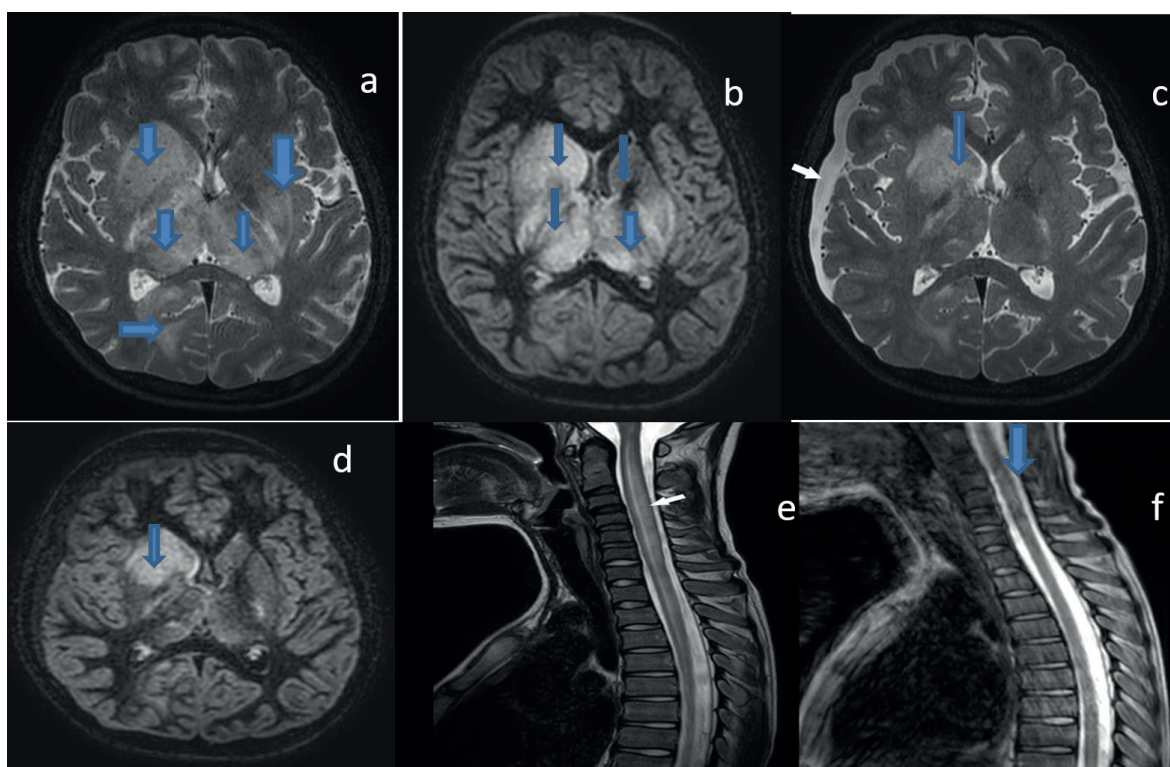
a-b) T2 axial and axial double inversion recovery (DIR) sequences of brain magnetic resonance imaging (MRI) study revealed no contrast enhancement or diffusion limitation, but marked signal increase, in the right caudate nucleus, bilateral lentiform nuclei, bilateral thalami, partially internal and external capsules, both occipital lobes (predominantly right side) and left hippocampus, and bilateral amygdala (blue arrow). c-d) Axial T2 and DIR sequences of the control brain MRI detected regression in the findings, being more pronounced in the bilateral thalamus (blue arrow). In addition, a newly developed subdural effusion (white arrow) was observed on the right side. e) On cervical MRI, there was a central signal increase (myelitis?) of a slightly expansive character in the cervicothoracic spinal cord (white arrow), which was more prominent in the cervical region; there was only millimetric punctate enhancement at the C4 level, but no enhancement was observed in other parts. f) Sagittal T2 sequences spinal cord expansion signal increase regressed in post-treatment control spinal MRI (blue arrow).
